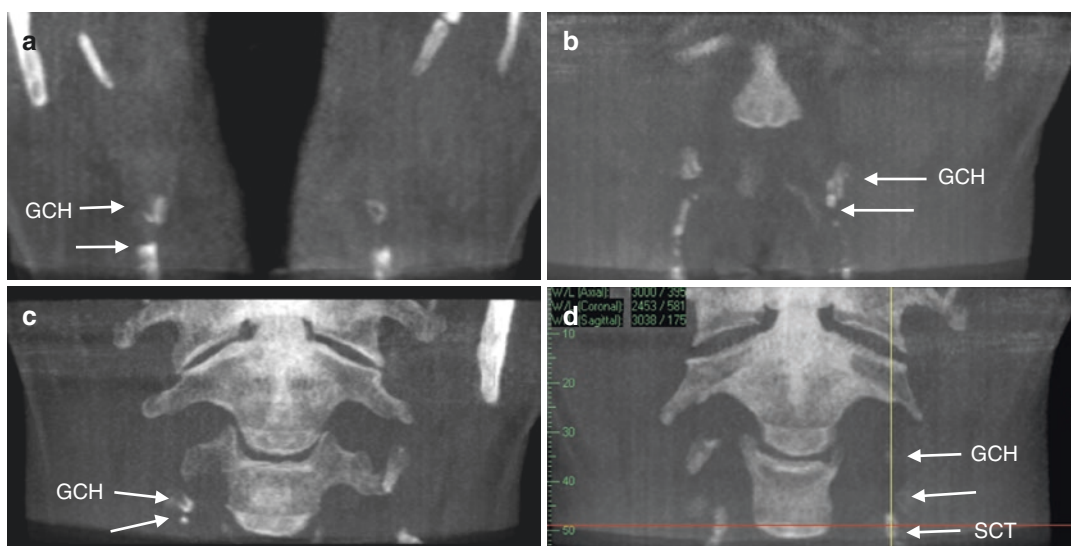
Axial medium slice (10–20 mm) MIP CBCT images from four different patients (a–d) demonstrating the consistent location and appearance of the CTC (*arrow*)
